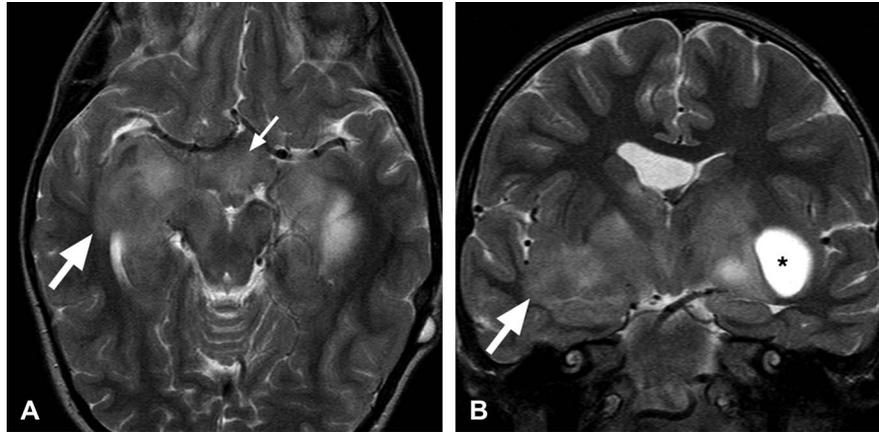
T2 axial (A) and coronal (B) MRI in a child with NF1 and a chiasmal glioma (*small arrow*) revealing extension into the optic radiations in the temporal lobes, worse on the right (*large arrows*), and a cyst in the left optic tract (asterisk). Note the compressed temporal horn of the left lateral ventricle can be seen below the cyst.
